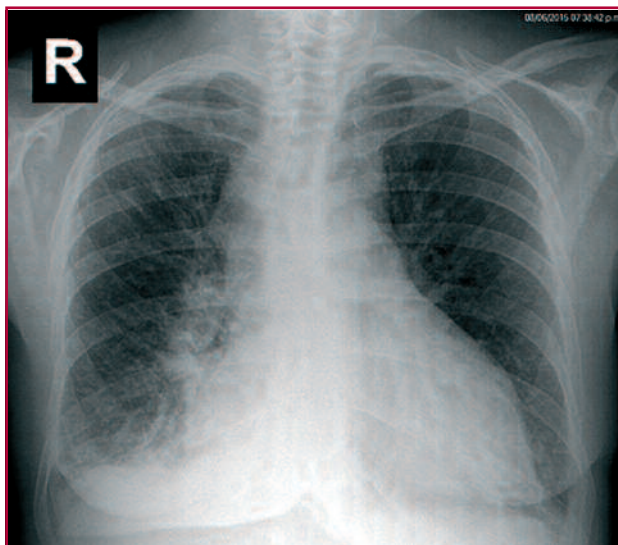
Chest X-ray showing signs of bilateral venous capillary hypertension.
